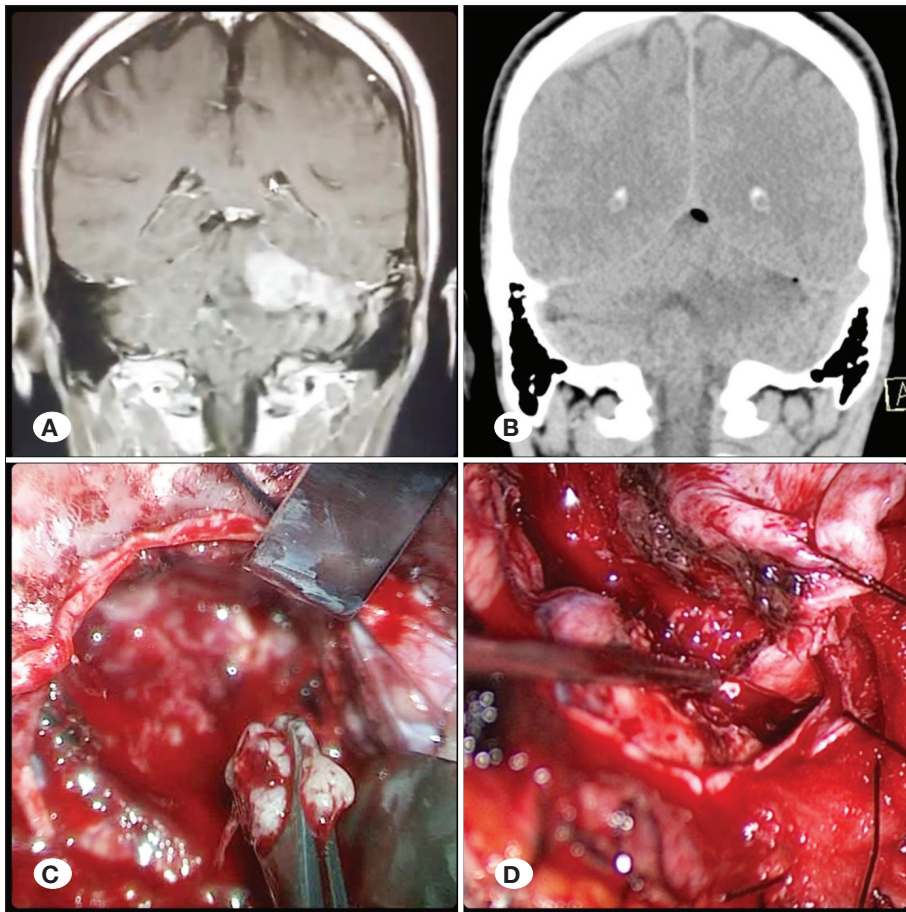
Patient #10. A) Preoperative T1W contrast enhanced coronal MRI. B) Postoperative coronal reconstructed CT scan. C) Piecemeal tumor removal. D) Gross total resection (GTR) confirmed.
